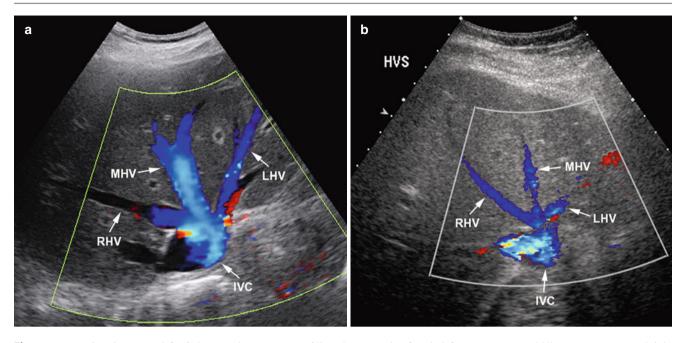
Hepatic veins. (a) and (b) Color Doppler sonograms of liver demonstrating flow in left (*arrow*, *LHV*), middle (*arrow*, *MHV*), and right (*arrow*, *RHV*) hepatic veins as they converge into the inferior vena cava (*arrow*, *IVC*)
